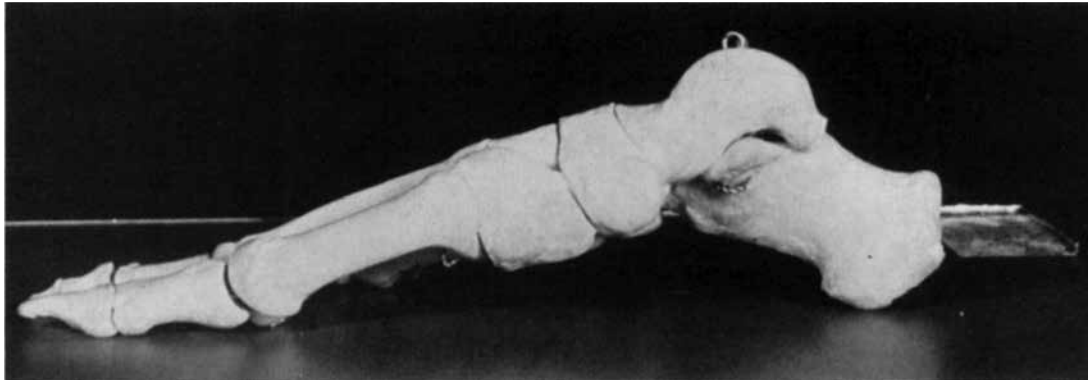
Medial side of the model positioned for a standard dorsoplantar radiograph. Note that the longitudinal axis of the tarsal navicular is oriented so that it is oblique to both the x-ray beam and the surface of the film. Partial fractures of the proximal articular border will be obscured in this position.
